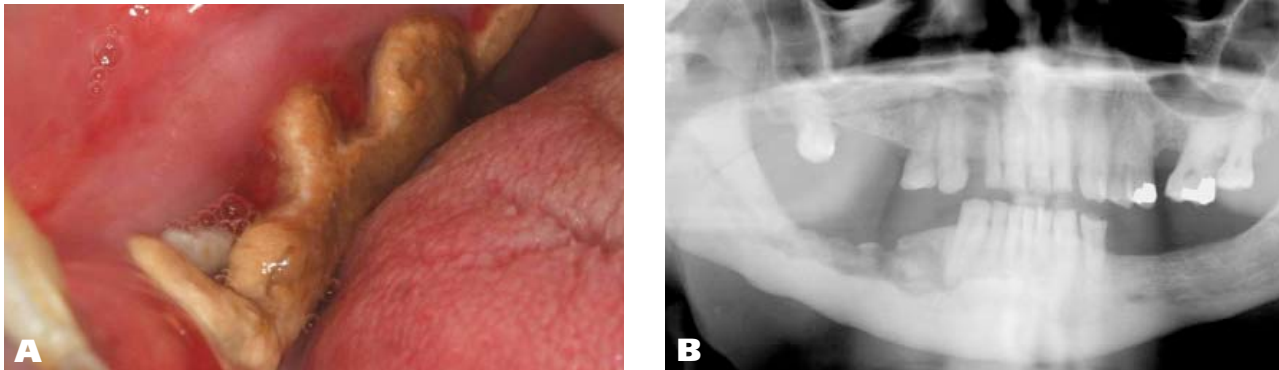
Intraoral photograph of a patient with osteonecrosis of the jaw. B. Panoramic radiograph of the same patient.
